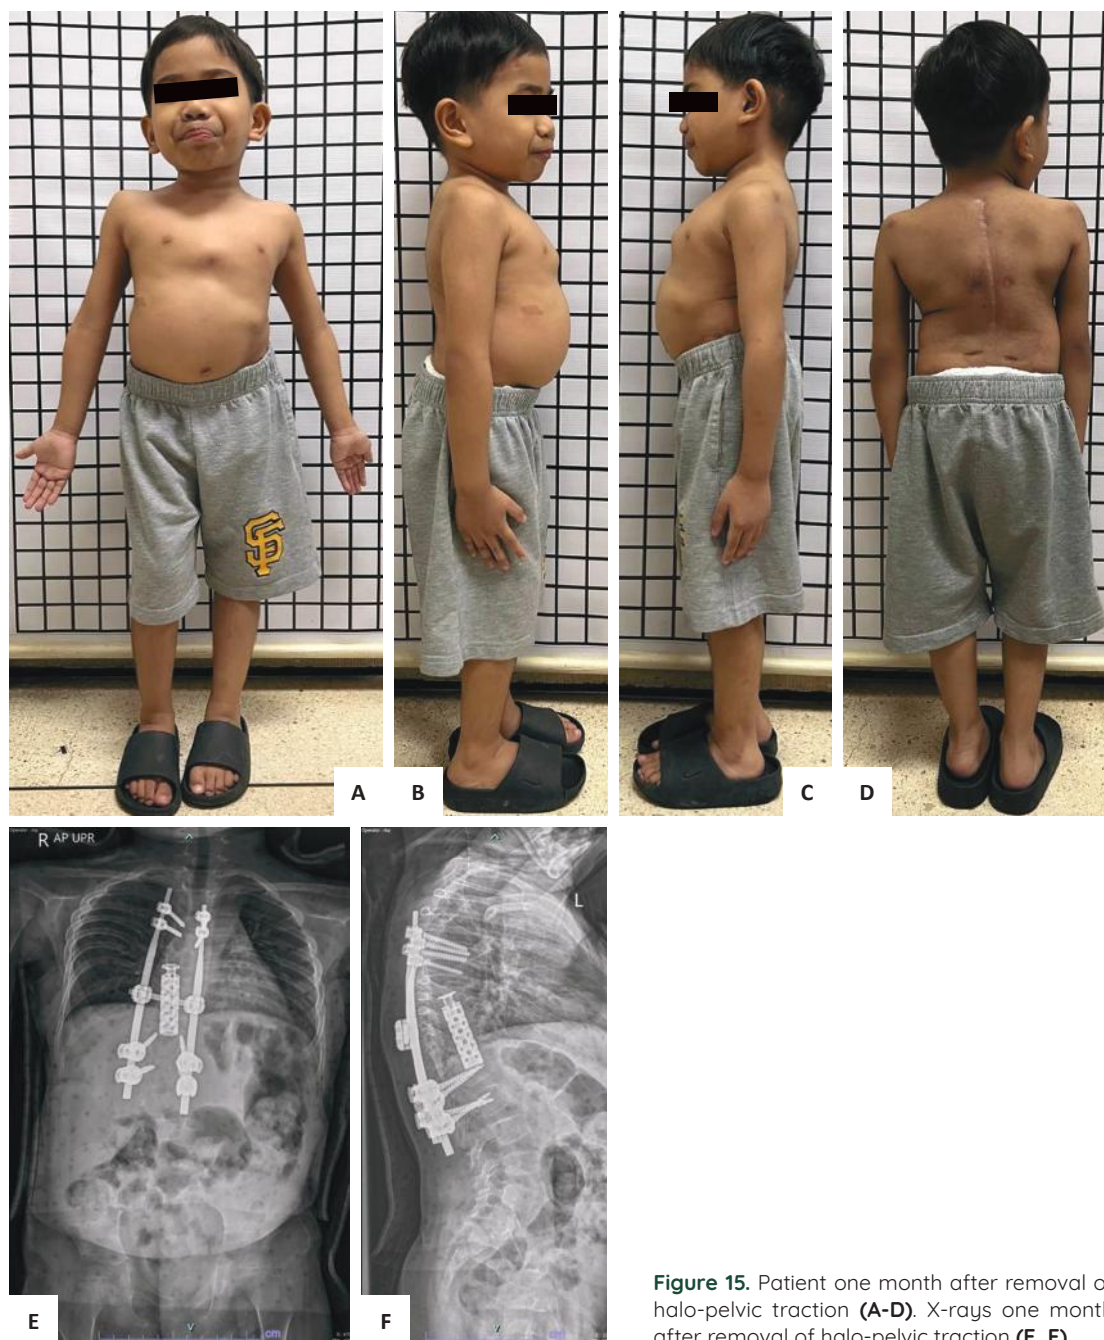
Patient one month after removal of halo-pelvic traction (A-D). X-rays one month after removal of halo-pelvic traction (E, F).
